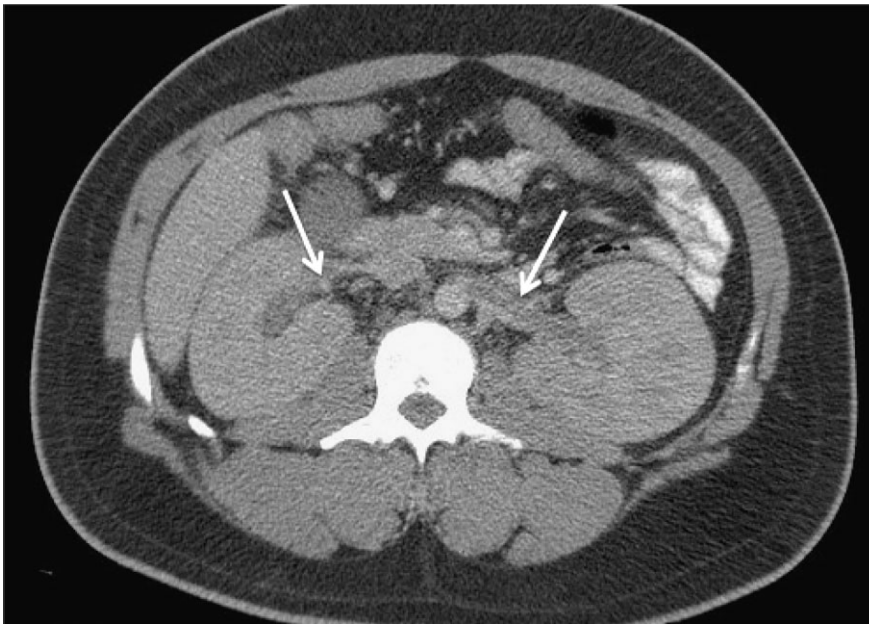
Computed tomography with contrast showing thrombus within both renal veins (white arrows).
